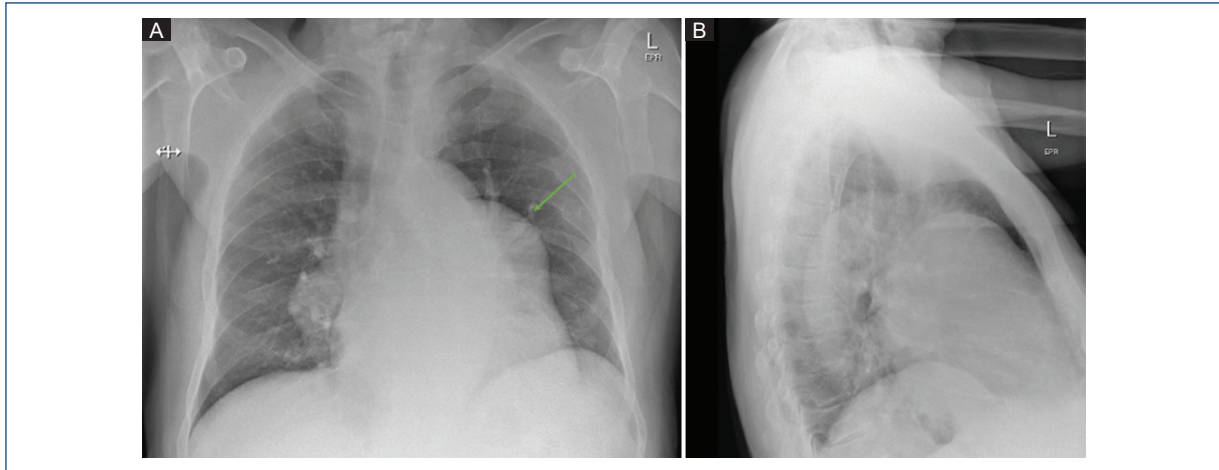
A and B: frontal and lateral chest radiographs demonstrate significant bilateral hilar enlargement, more prominent on the left (arrow).
